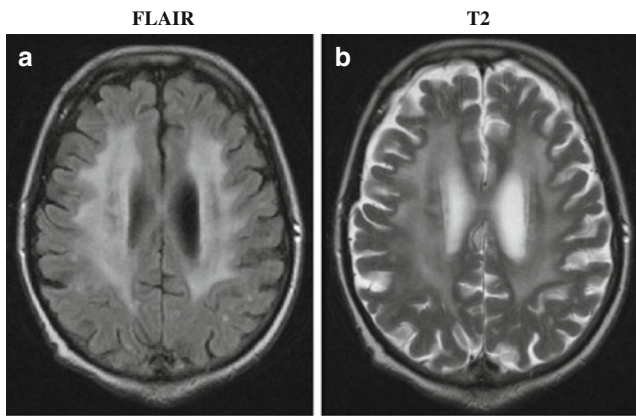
Radiation-Induced Diffuse White Matter Abnormality: a 73 year-old man presented with a single brain metastasis from colon cancer. He received 37.5 Gy in 2.5 Gy fractions of whole brain radiation followed by radiosurgery boost. He recurred with multiple new enhancing lesions (all subcentimeter) suspicious for metastasis. He received 21.6 Gy in 1.8 Gy fractions of repeat whole brain radiation. Six months later, his MRI revealed diffuse white matter changes on both FLAIR (a) and T2 (b) sequences
